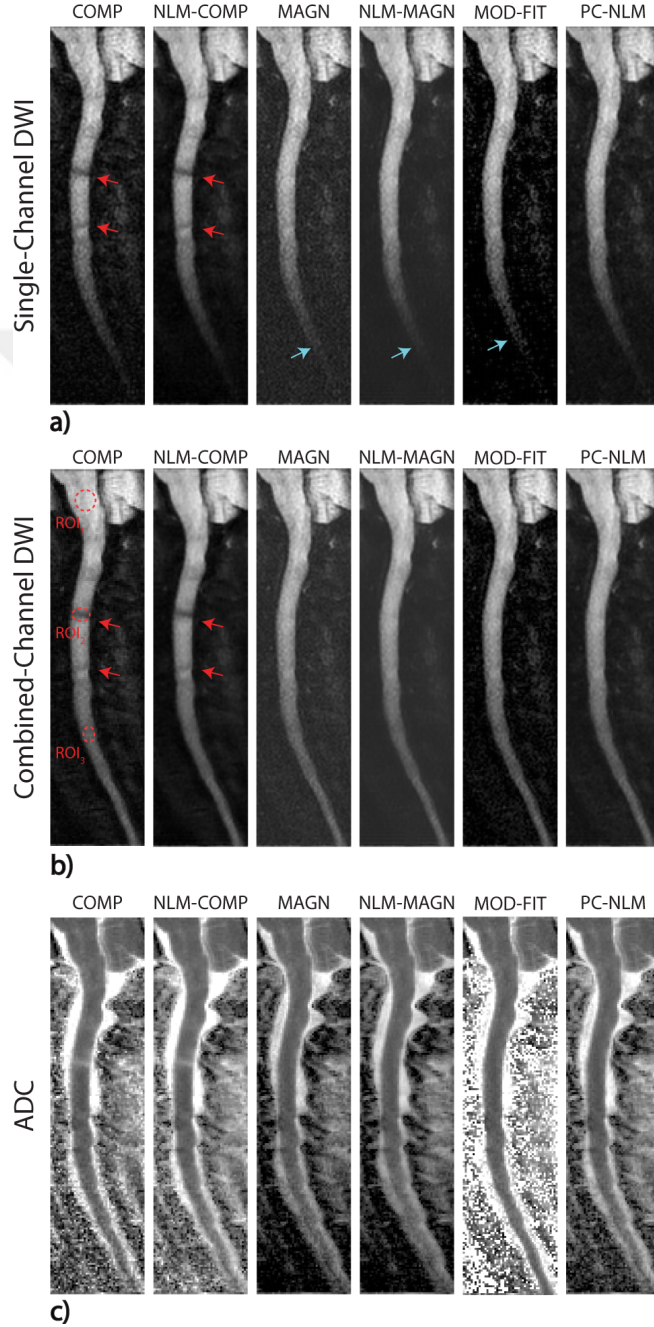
Results for in vivo DWI of the spinal cord for the first subject. Images with diffusion-encoding along the A/P direction are displayed. a) Reconstructions of single-channel images. Local signal cancellations due to phase errors are prominent in COMP and NLM-COMP (red arrows). MAGN, NLM-MAGN, and MOD-FIT overcome signal cancellations, but noise accrual or noise sensitivity occurs (blue arrows). b) Reconstructions of combined-channel images. Signal cancellations (red arrows) are still present in COMP and NLM-COMP. Although combining across channels improves depiction of the inferior parts of the spinal cord, noise amplification remains a problem in MAGN and NLM-MAGN. While MOD-FIT also benefits from combining across channels, the unnatural darkening in the background persists. In contrast, the proposed reconstruction suppresses signal cancellations and noise amplifications. For the quantitative analyses of the mean ADC values, three different ROIs were selected, as marked on the DWI image from COMP. c) ADC maps for all reconstructions. The mean ADC values in the selected ROIs are listed in Table 3.2.
